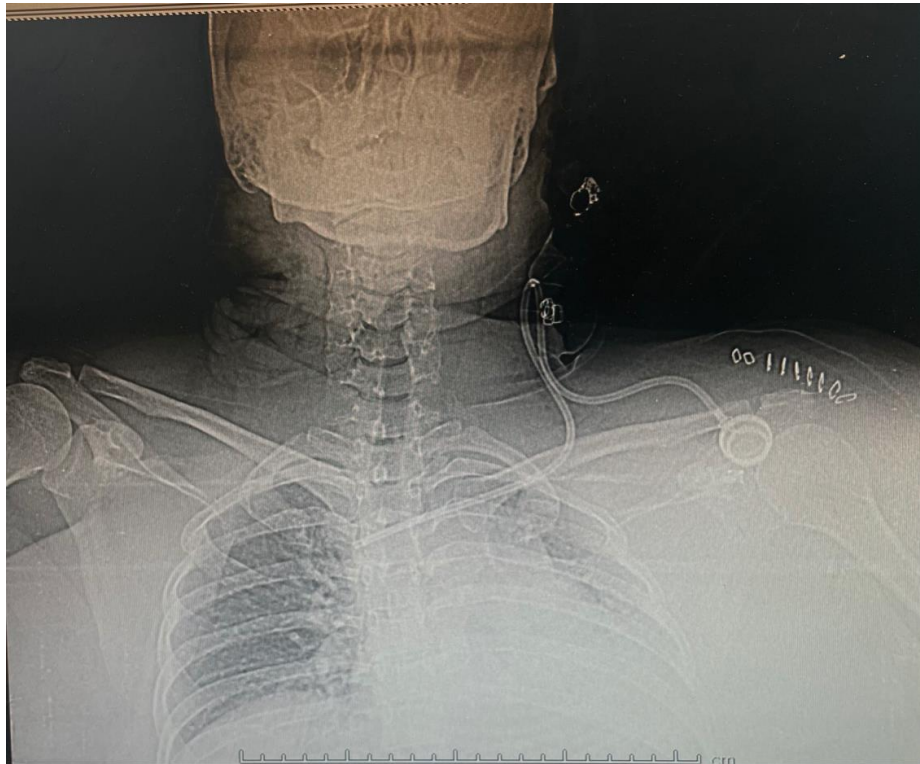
Chest radiograph demonstrating a kinked implanted venous access port and indwelling catheter.
